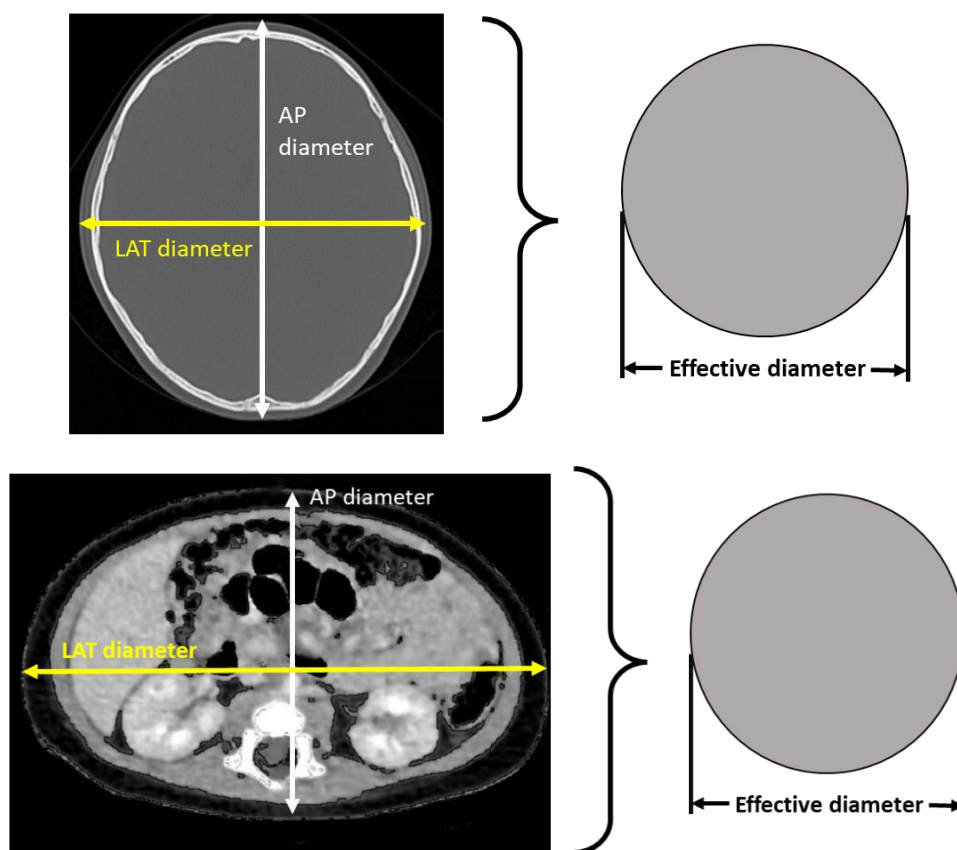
Measurement of AP and LAT diameters on axial CT images at head (top) and abdomen region (bottom).
